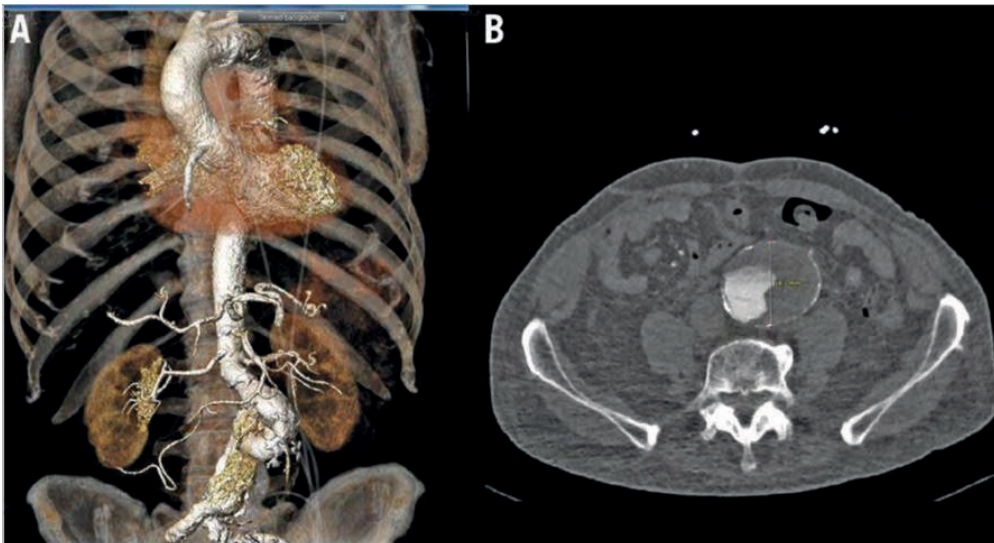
Imaging during work-up. A) A three-dimensional CT reconstruction of the fusiform infrarenal abdominal aortic aneurysm. B) Axial view of the fusiform abdominal aortic aneurysm.
